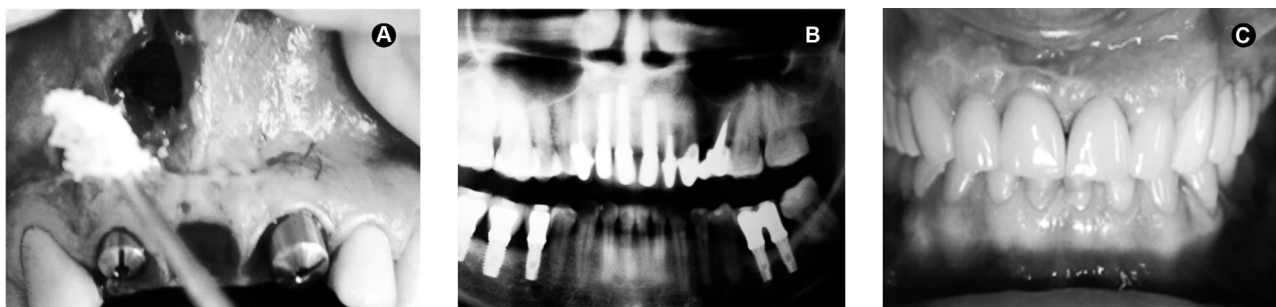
Panel of clinical and radiographic images of the case. A= Fulfilling of the surgical chamber with xenogenous bone graft after implant placement; B= Radiographic aspect at the 3-year follow-up visit after the definitive denture placement; C= Clinical aspect at the 3-year follow-up visit after the definitive denture placement.
